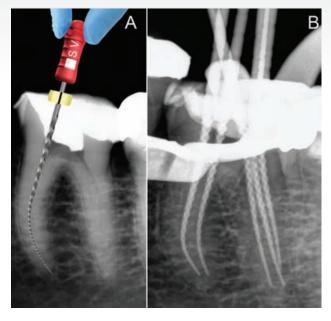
(a) Size 25 GuttaCore Verifier was used to check the root canal preparation; (b) the fit of the verifiers were confirmed radiographically.
